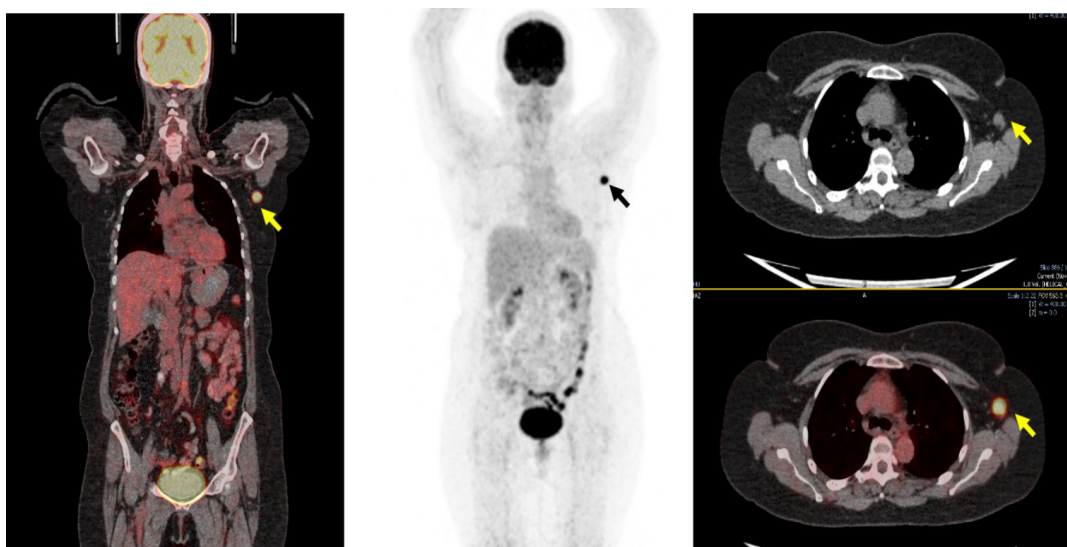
37 Years Female, Right Breast Cancer Survivor with COVID-19 Vaccine in Left Deltoid 04 Weeks back and has had a Surveillance ¹⁸FDG PET/CT Scan. Solitary enlarged hypermetabolic left axillary node seen (thick arrow) which turned out positive for metastasis on ultrasound guided fine needle aspiration.
